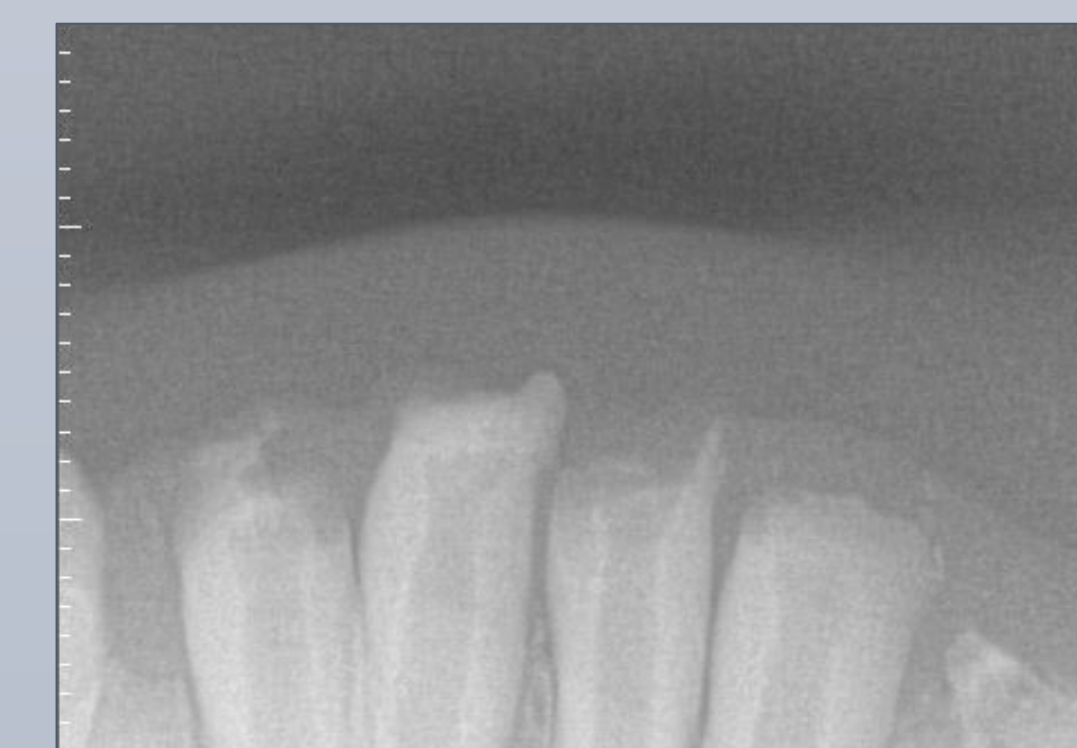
Mandibular Periapical 4/27/2022
